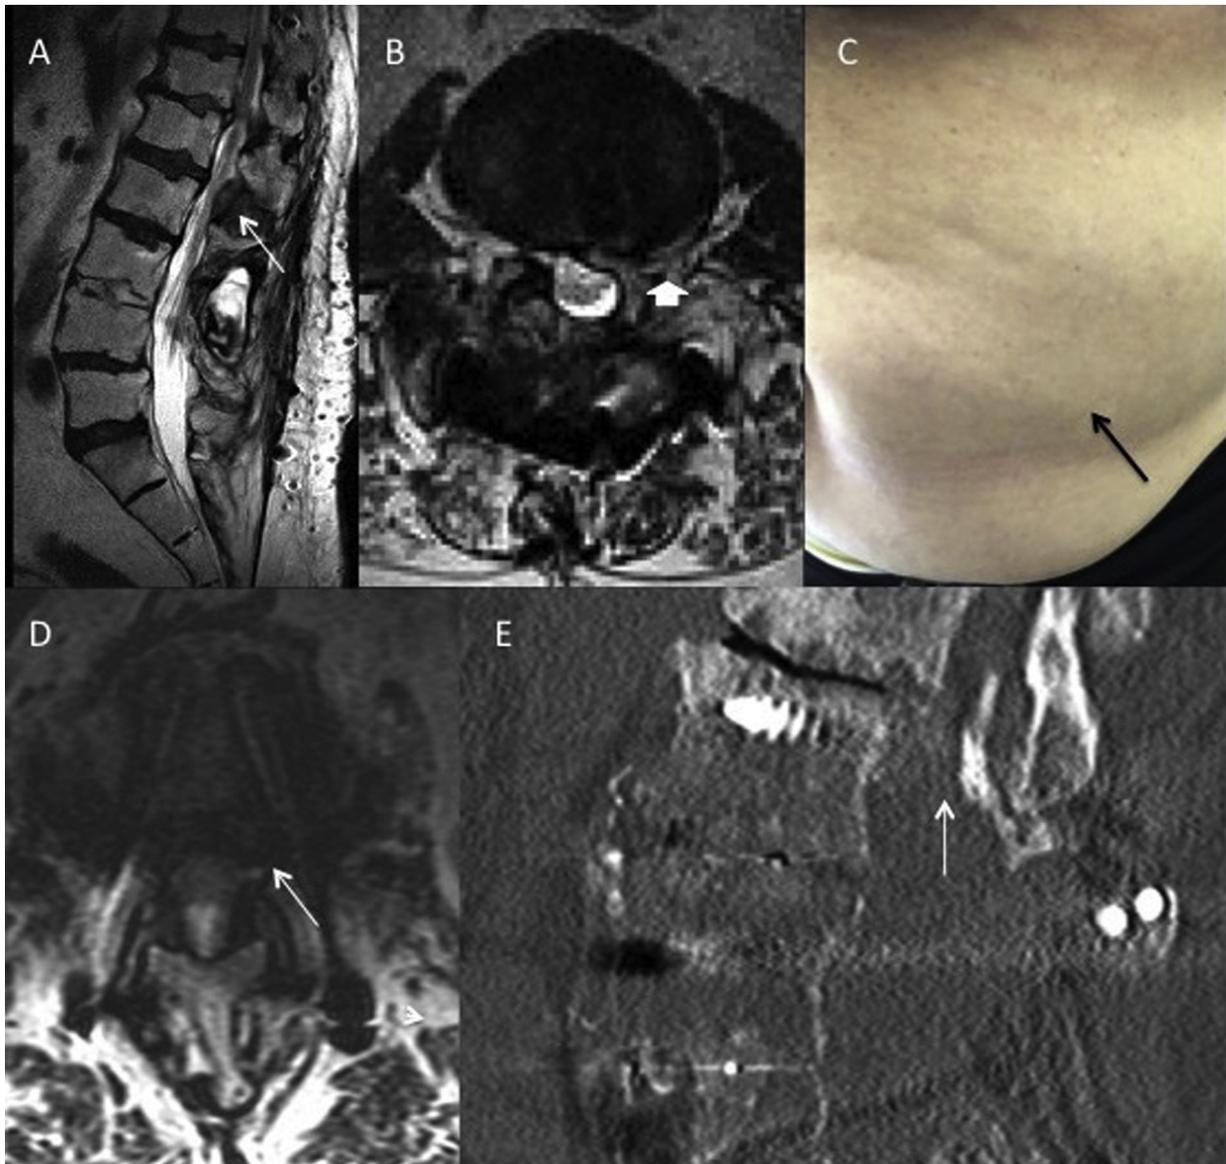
Patient images. (A) Patient #1 imaging showing a sagittal T2 MRI with facet hypertrophy from adjacent segment disease and resulting central canal stenosis (white arrow). (B) Axial T2 MRI showing epidural scar tissue and calcification at the left L1-2 foramen (thick white arrow). (C) Left sided abdominal bulge from unilateral flaccid abdominal wall musculature (black arrow). (D) Patient #2 imaging showing an axial T2 MRI with adjacent segment disease at the L1-2 level with resulting foraminal stenosis and impingement of the exiting left L1 nerve root (white arrow). (E) Sagittal CT showing calcified disc causing lateral recess and foraminal stenosis at the L1- 2 level (white arrow).
